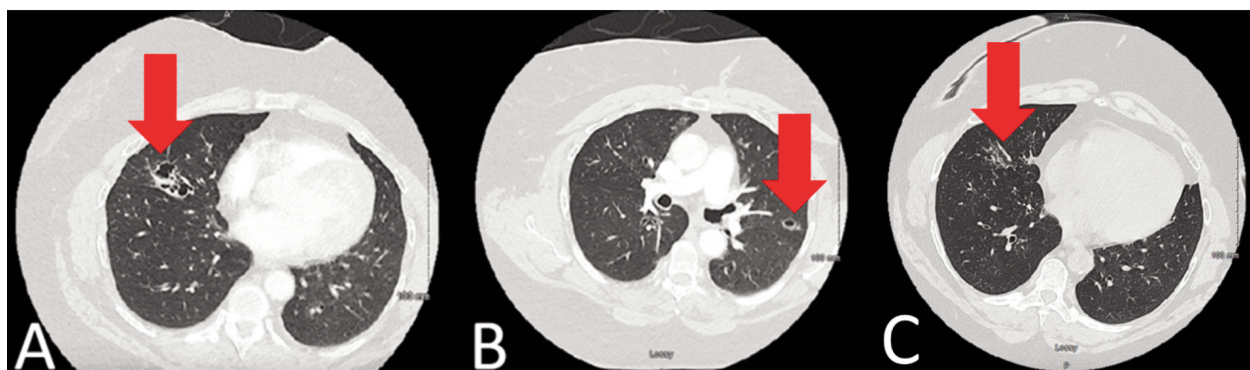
Computed Tomography (CT) pulmonary embolism with angiography and contrast obtained on day nine of admission due to persistent oxygen requirements and prolonged hospital course to assess for pulmonary embolism. Imaging negative for acute pulmonary embolism. Noted A) new diagnosis of right middle lobe predominant bronchiectasis; B) left upper lobe with small cystic areas near the fissure and with prominent apical ground glass opacities. Repeat CT chest without contrast six weeks following discharge with noted C) interval resolution of cystic lung changes with residual scarring and no focal consolidative lung changes or ground glass opacities.
